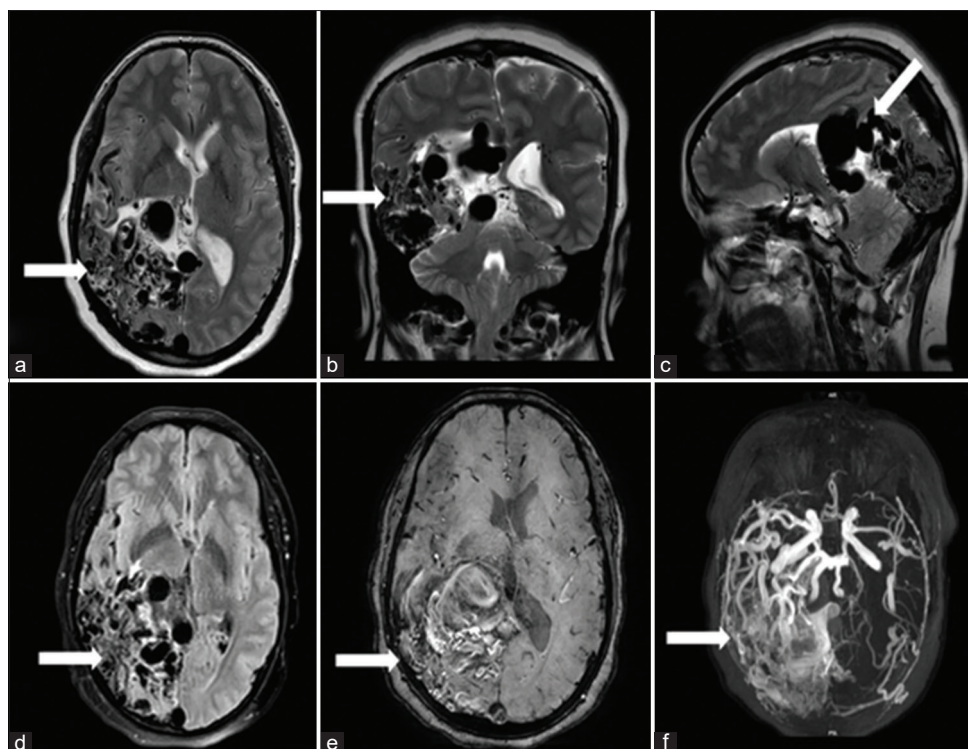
Magnetic resonance imaging brain of a pregnant patient in the early third trimester, showing an arteriovenous malformation (AVM) in the right temporo-parieto-occipital lobe (solid arrows) seen as multiple serpiginous flow voids on (a-c) images. (a) T2WI image in axial showing evidence of midline shift toward the left side with effacement of ipsilateral lateral ventricle (b) T2WI in coronal showing effaced lateral ventricle. (c) T2WI in sagittal showing dilated draining vein of Galen (arrow). (d) T2 FLAIR images in axial showing hyperintense foci suggestive of gliosis. (e) Susceptibility weighted image showing a few patchy hypointense susceptibility foci of bleed (arrow). (f) Time-of-flight angiography images showing the abnormal tuft of AVM (arrow)
